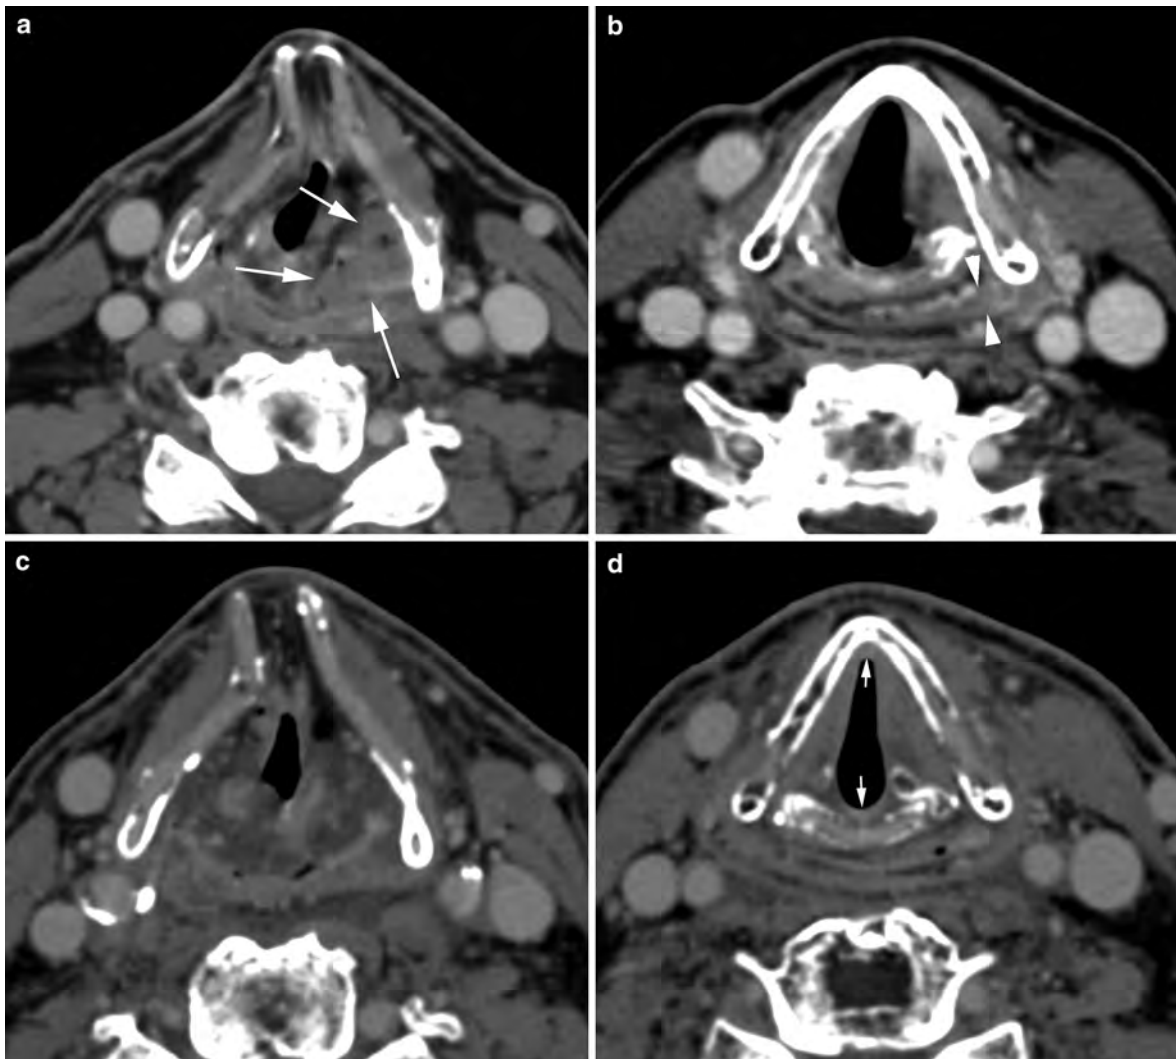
Axial contrast-enhanced CT images through the false (a) and true (b) vocal cord level reveals a pyriform sinus cancer (arrows in a) of <math><6.5\text{ ml}</math> with minimal involvement at the pyriform sinus apex (arrowheads in b) that carries a favorable prognosis to be controlled at the primary site with radiation
